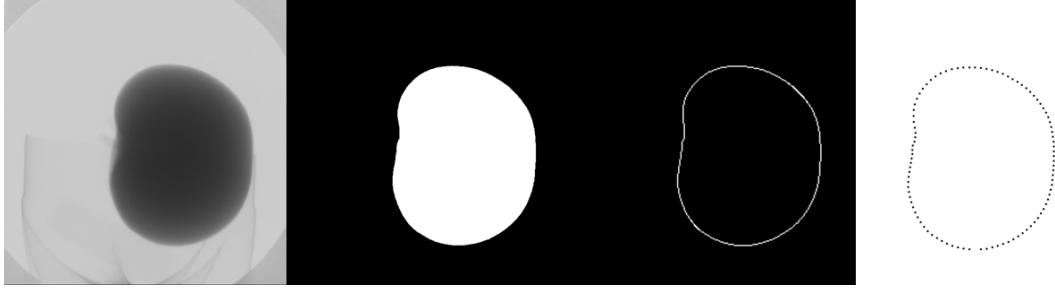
The original radiograph (a) first is thresholded (b) and the edge is detected using a Canny edge detector (c). The resulting edge was resampled onto 100 equi-angular points (d).
